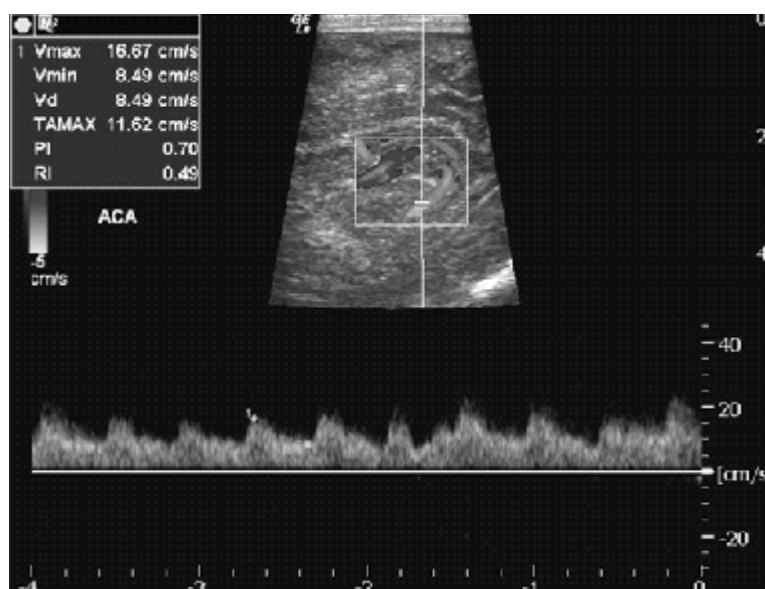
Color Doppler indices of anterior cerebral artery in severe asphyxia
